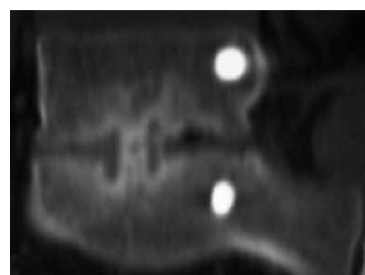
CT after 6 months reveals signs of fusion through CAGE.
